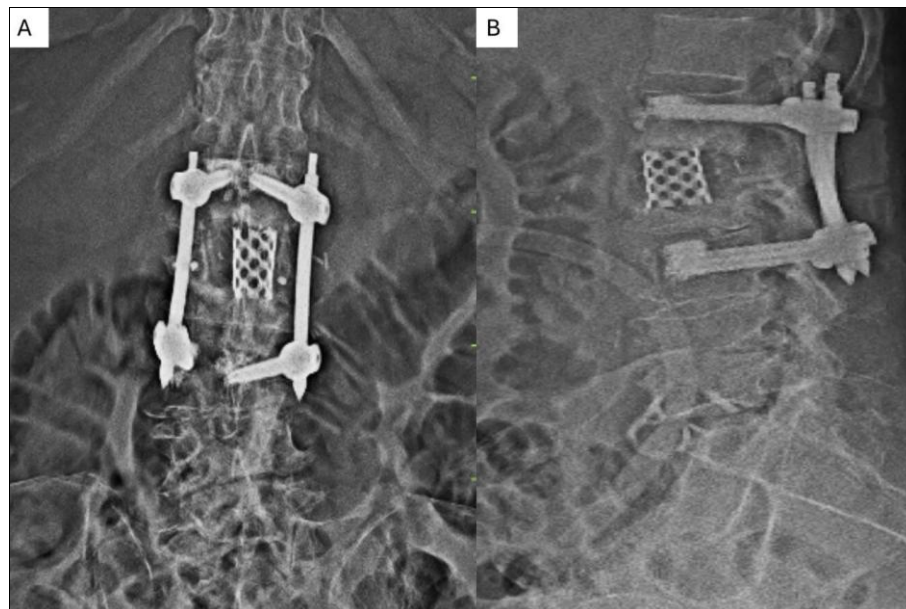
Post-Revision surgery X-ray Lumbosacral spine – showing L1-2 interbody fusion with titanium mesh cage and bone graft, L1-3 posterior fixation with pedicle screws and rods. A) Anteroposterior view B) Lateral view
